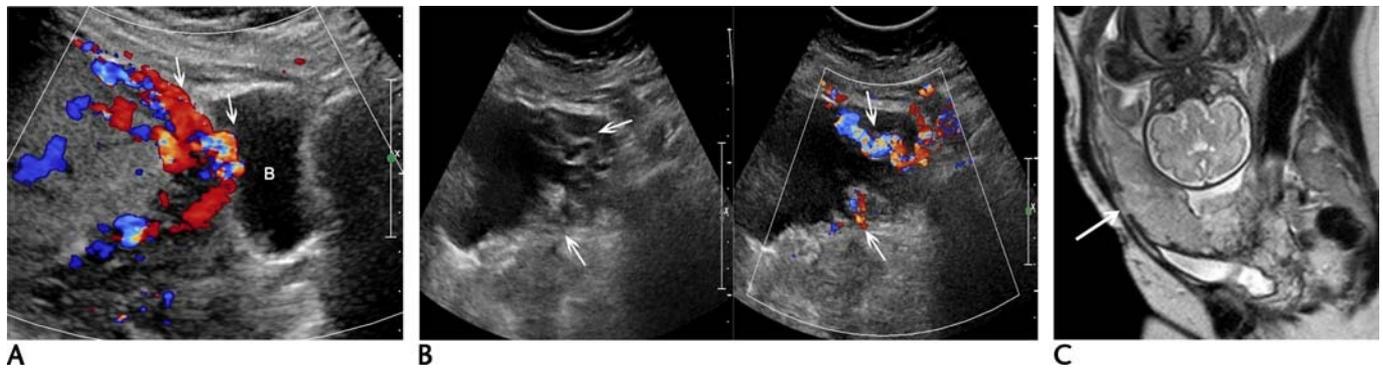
Placenta percreta associated with complete placenta previa in a patient with history of 2 prior cesarean sections. A, Gray-scale sagittal Doppler ultrasound image shows a gradually thinning myometrial layer (arrows), which becomes indistinguishable between the uterus and the bladder (B) interface, with an absent subplacental clear space (PL: placenta). B, Sagittal gray-scale and color Doppler images in the same patient show numerous irregular vessels with turbulent flow extending into the bladder wall (arrows). At delivery, the patient underwent cesarean section and hysterectomy, as well as bladder repair. C, Sagittal single-shot fast spin-echo MR image in a different patient at 28 weeks gestation, with previous cesarean sections shows invasion of the placenta into the anterior abdominal wall just above the cesarean section scar and focal interruption of the myometrium (arrow). Placenta percreta was confirmed at surgery and on pathologic evaluation.
